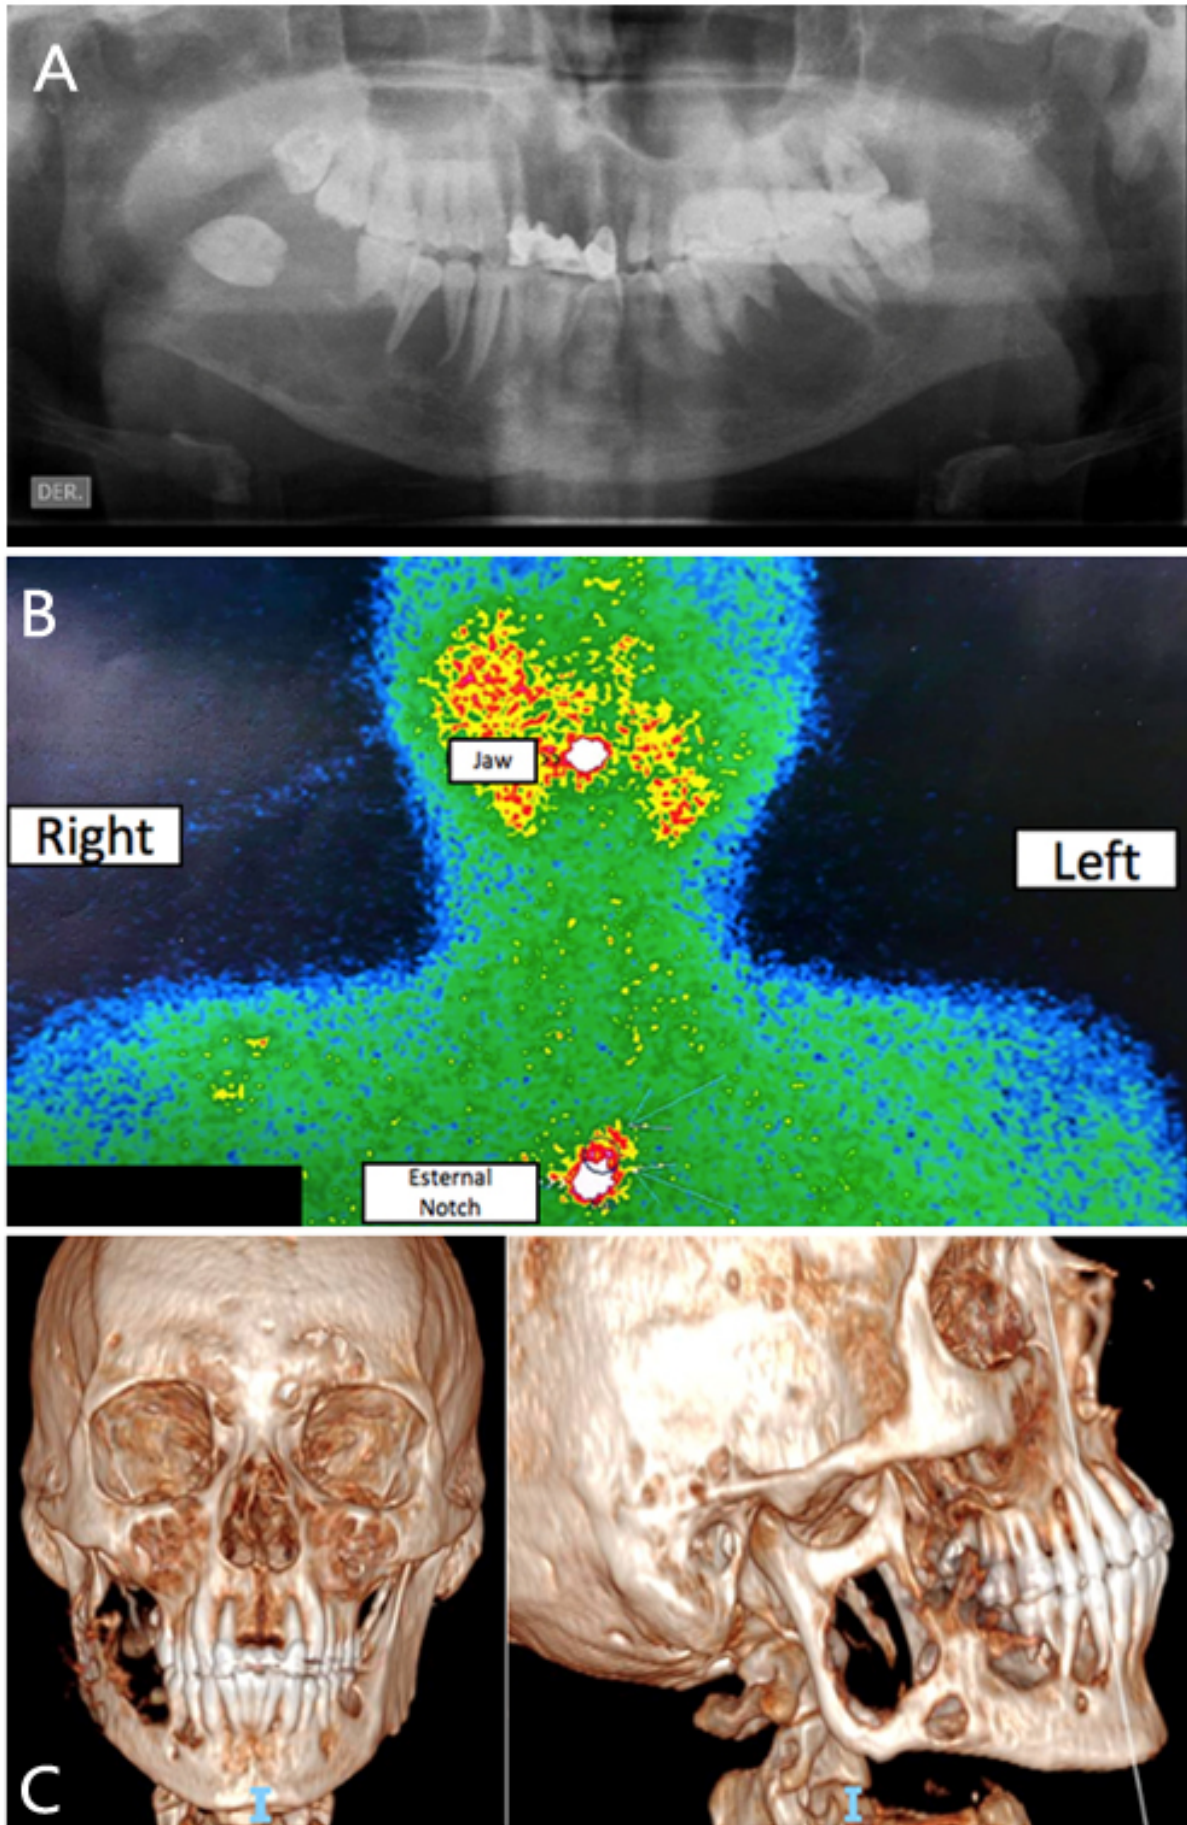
A. Orthopantomogram showed large unilocular radiolucency on the right side, extending from the body, angle, and ramus of the jaw. B. A parathyroid technetium scintiscan findings were showing abnormally high uptake is observed at the central region of superior mediastinum interpreted as parathyroid adenoma with a possible brown tumor of mandible. C. 3D reconstruction at the level of the body, angle, and ramus of the mandible, a lytic ovoid lesion, conditions bone destruction of the mandible from the first premolar to the notch, and the coronoid process; measuring approximately 7.2 x 4.7 cm.
